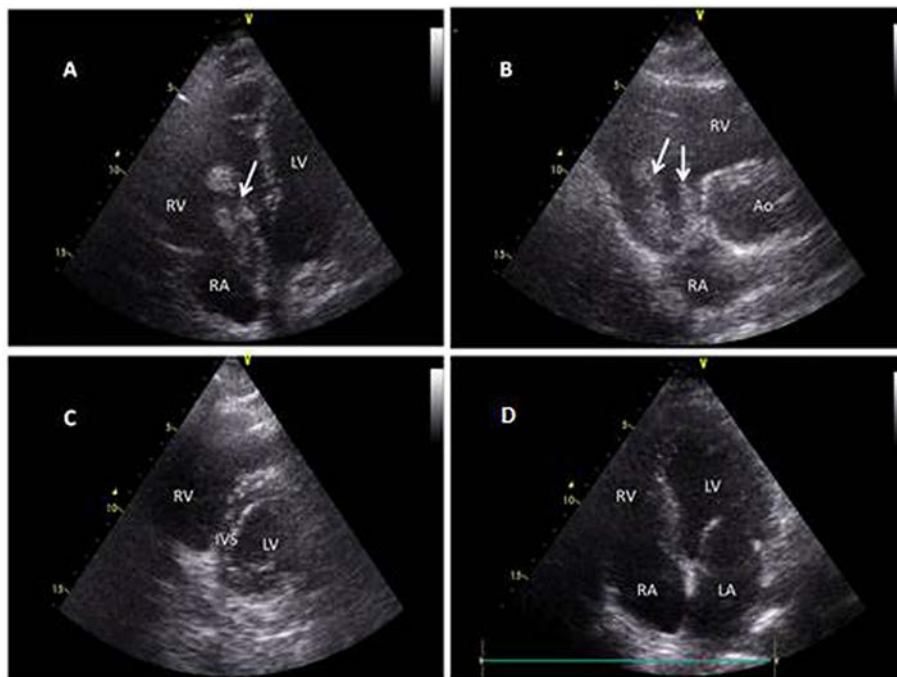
Point-of-care-cardiac ultrasound (day-2) performed on our critically ill patient with COVID-19: modified four-chamber (A), and short-axis at the level of aortic valve (B) views depicting a large free-floating thrombus (white arrows) migrating to the pulmonary circulation along with severe RV dilatation/dysfunction. Also, on day-2, another short axis view (C) shows a D-shaped left ventricle in systole due to right ventricular pressure overload. On day-5 post-thrombolysis, four-chamber view (D) shows restored right ventricular function. Abbreviations: RA = right atrium, RV = right ventricle; LA = left atrium; LV = left ventricle; IVS = interventricular septum, Ao = aorta.
